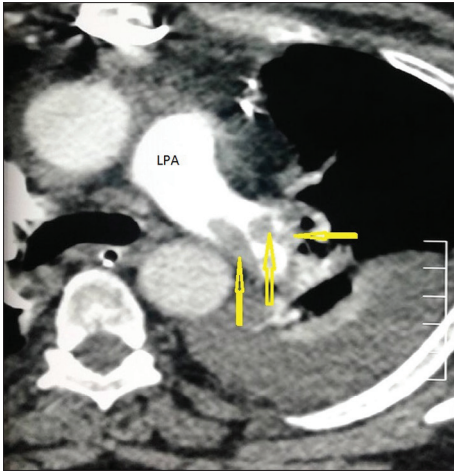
Computed tomographic pulmonary angiography after contrast injection shows multiple filling defects in segmental branches of the left pulmonary artery. Yellow arrow shows filling defects which are suggestive of multiple thrombi
